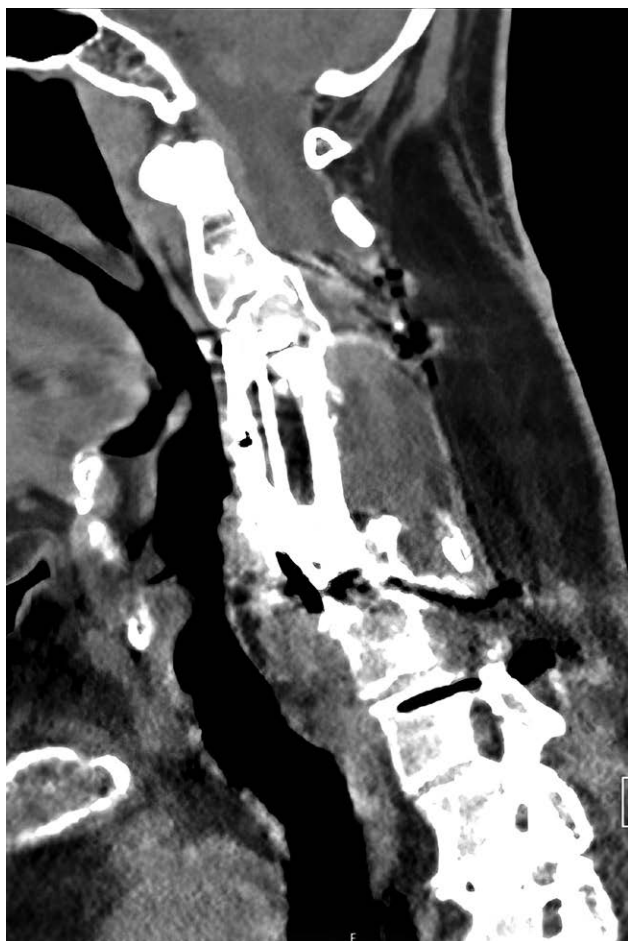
CT scan of patient 13 performed 4 years postoperatively. The scan is showing the reconstructed area in the sagittal plane. The flap is seen posterior to the osteosynthesis material and fibula graft. No dead space could be detected on the CT scan, which showed only minimal artifacts from hardware.
